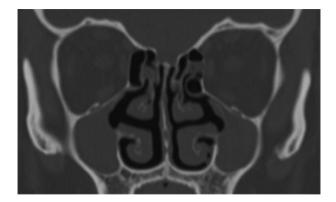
Coronal computed tomography scan of patient one, demonstrating complete bilateral maxillary sinus opacification and hypoplasia, and uncinate process lateralisation.
